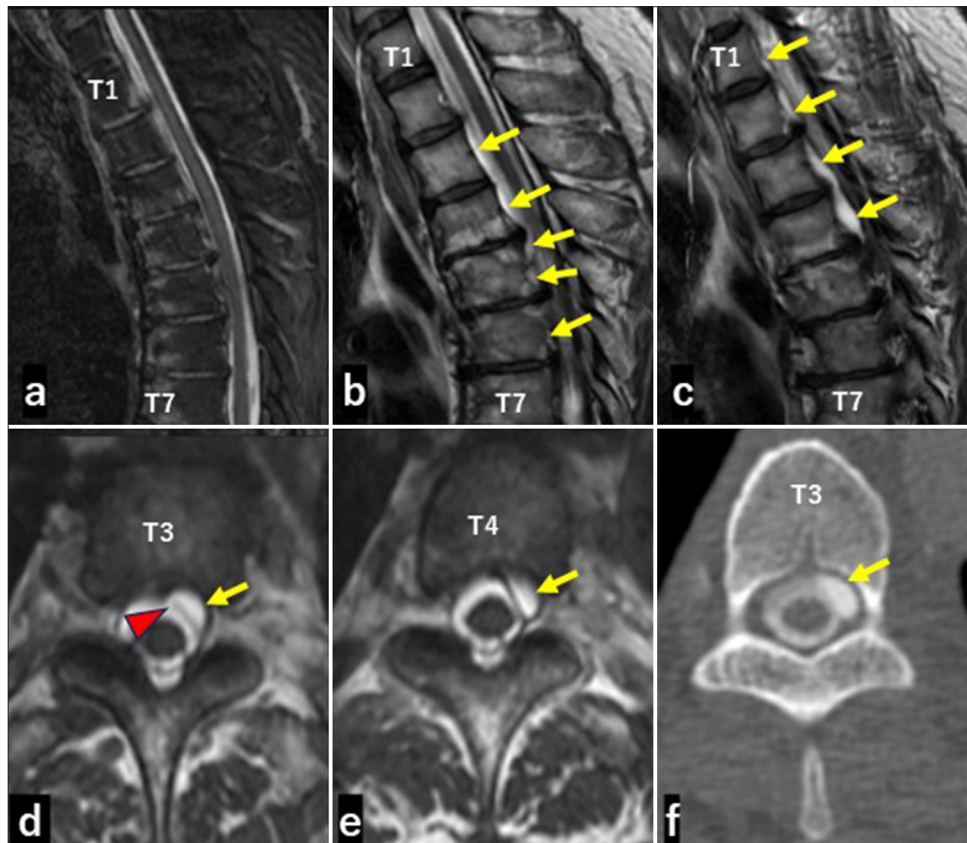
Neuroimaging of the thoracic spine. (a) T2*-weighted midline sagittal magnetic resonance imaging (MRI) of the thoracic spine showed hemosiderin deposition on the upper thoracic spinal cord and osteophytes at the T3-T4 and T4-T5 disc levels. (b, c) T2*-weighted off-midline sagittal MRI showed fluid collection outside the dura mater at the T1-T6 level (arrows). (d, e) Axial constructive interference in steady state-weighted MRI showed a left antero-lateral extradural fluid collection at the T3 and T4 levels (arrow). It also showed a dural defect at the T3 level (arrowhead in d). (f) A computer tomographic myelogram showed that the contrast material in the cerebrospinal fluid leaked into the extradural space (arrow).
